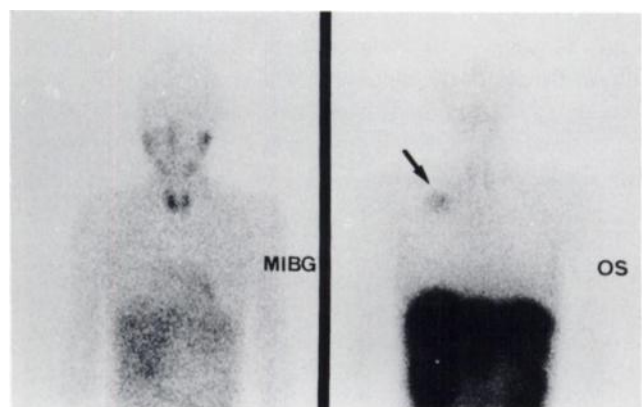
Patient 5 with a malignant pheochromocytoma. Presentation as in Figure 1. No abnormal uptake is seen on MIBG scan but octreotide scintigraphy demonstrates a right lung metastasis (arrow).
